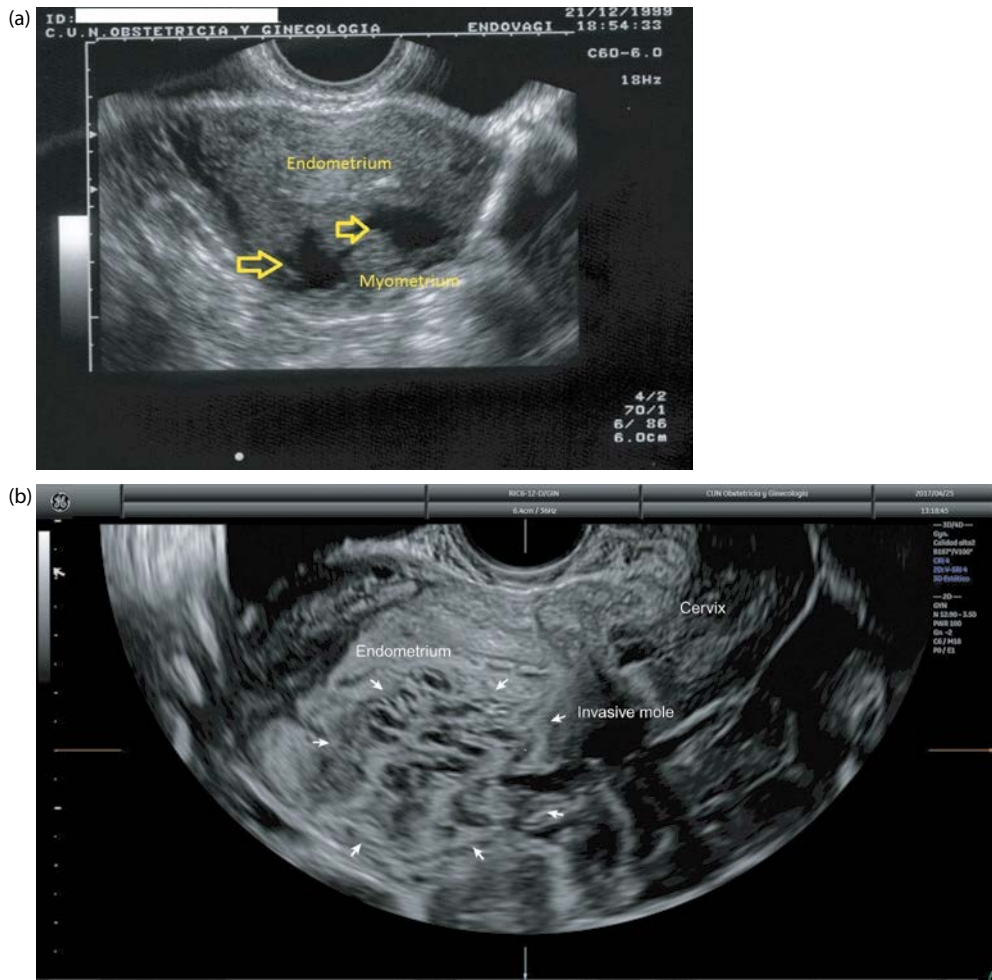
Transvaginal ultrasound showing two cases of invasive mole (a and b). An irregular mass with irregular cystic areas (arrows) is observed within the posterior myometrial wall.
